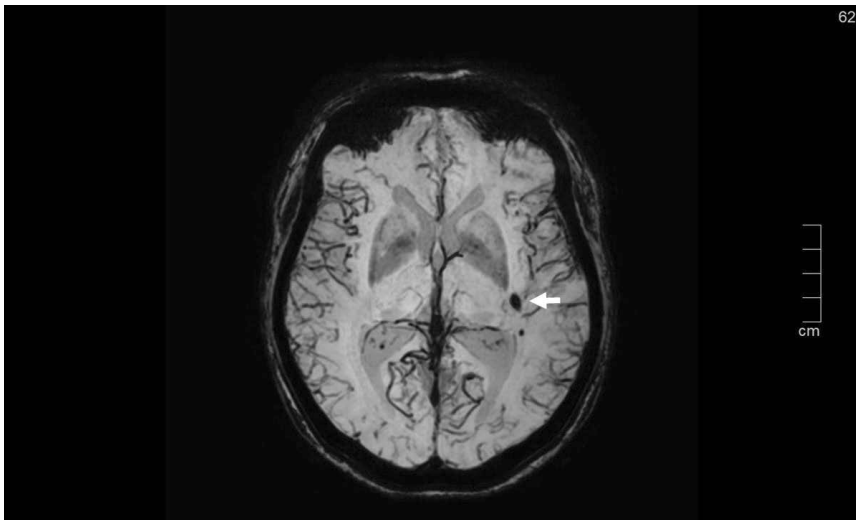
Cerebral microbleeds (largest marked with arrow) in a brain MRI-image (SWI).
